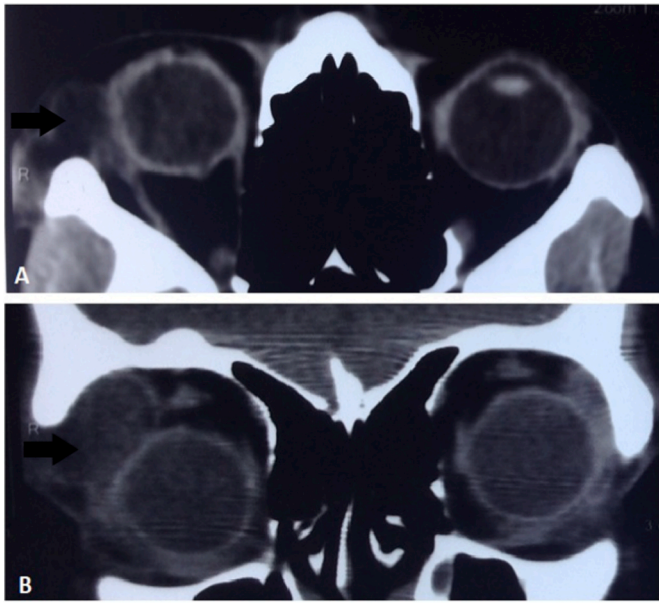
22-year-old female with a dumbbell-shape dermoid cyst. (Case NO.3). A: Axial and B: Coronal orbital computed tomography (CT) shows a hypodense mass. A large part of the mass is located in the anterior orbit and a small part is located in the temporal fossa.
